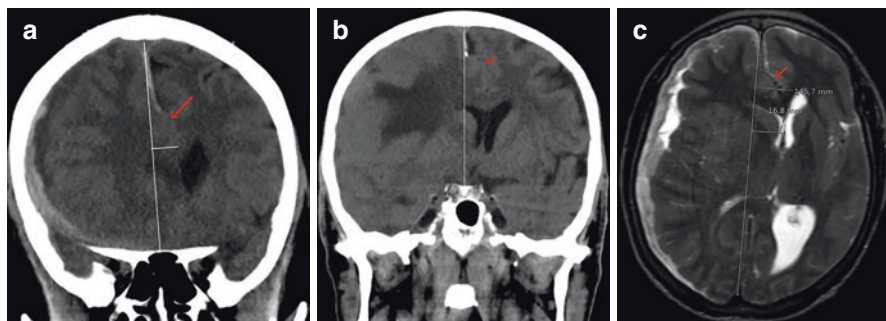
Subfalcine herniation samples are observed on CT (a, b) in the coronal plane and T2 MRI (c) in the axial plane, in different patients. On coronal CT images (a, b), in addition to the midline shift, the right cingulate gyrus is displaced from under the free edge of the falx to the left (red arrow). In axial T2 MRI (c), in addition to the cingulate gyrus, the right anterior cerebral artery is also observed to be displaced to the left. In all cases, due to the compression of foramen Monro, enlargement of the contralateral lateral ventricle (hydrocephalus) is noted
